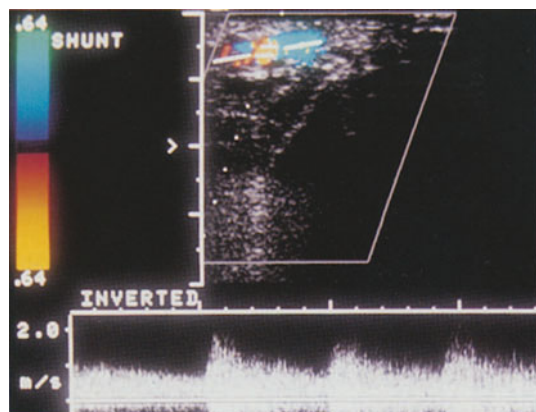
(left) Typical appearance of an anastomosis; the Doppler waveform shows spectral broadening (filling in of the area under the wave outline due to many different frequency components occurring simultaneously because of turbulence)
